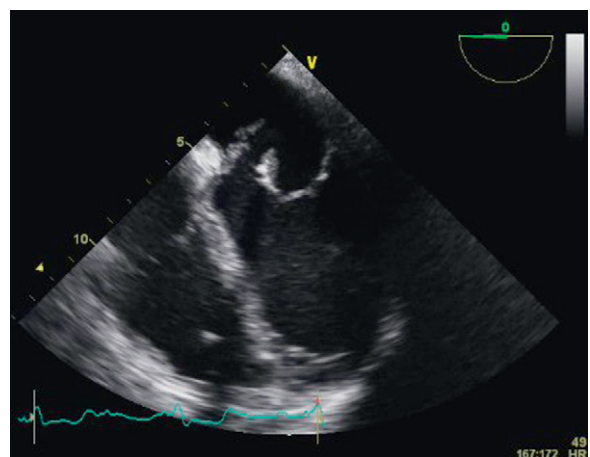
Transesophageal echocardiography showing large vegetations on the anterior mitral valve leaflet.
